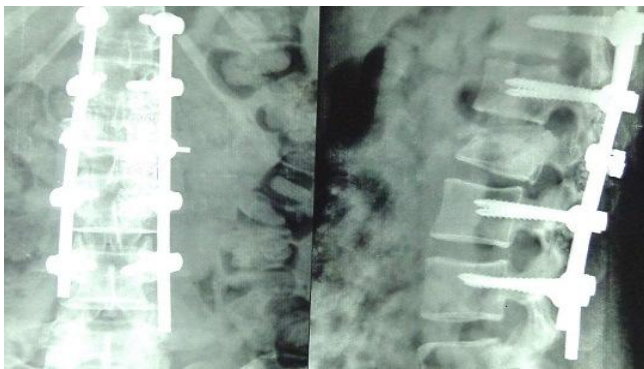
AP and Lateral X-ray after 12 weeks
